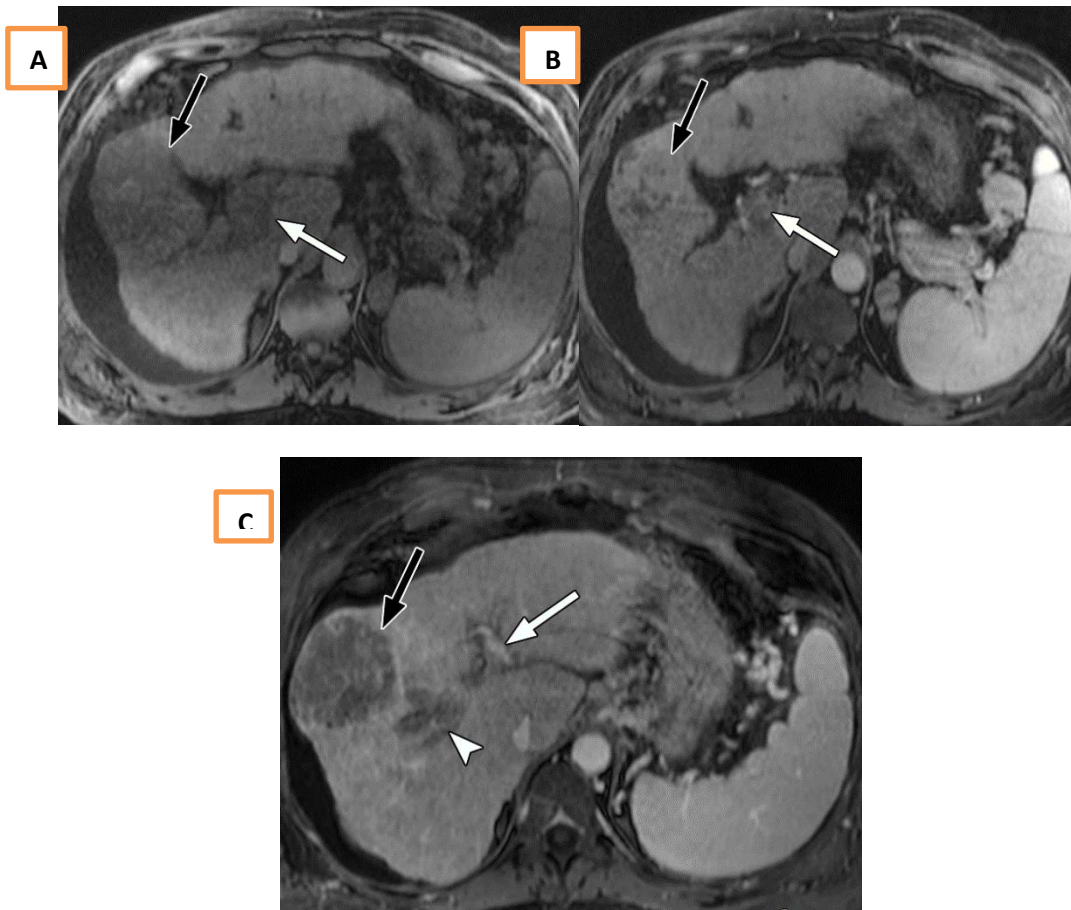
Dynamic MRI study of a 67-year-old male patient with liver cirrhosis showing HCC with malignant portal vein thrombosis
